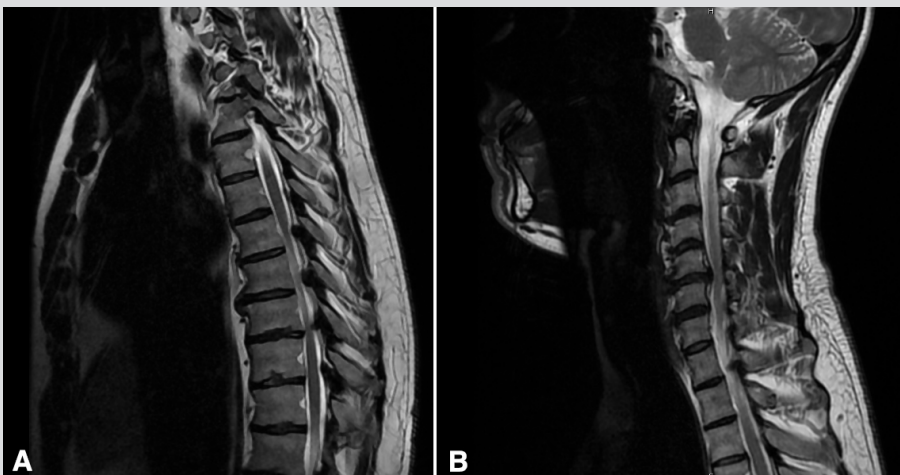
MRI of the cervical and dorsal spine showing anterior osteophytes
